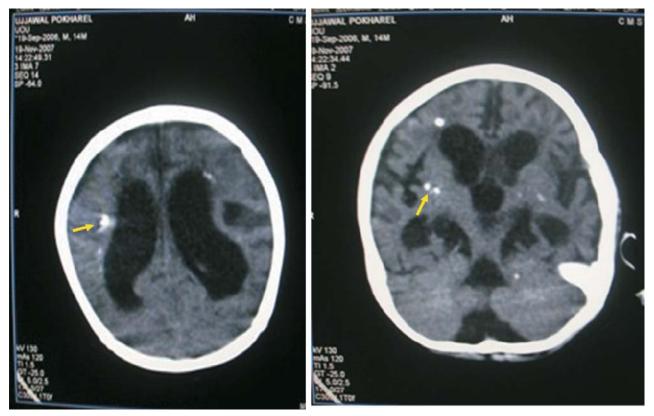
CT Scan showing multiple calcification (periventricular, subcortical and grey mater white mater junction), gross ventriculomegaly and mild cerebellar hypoplasia
